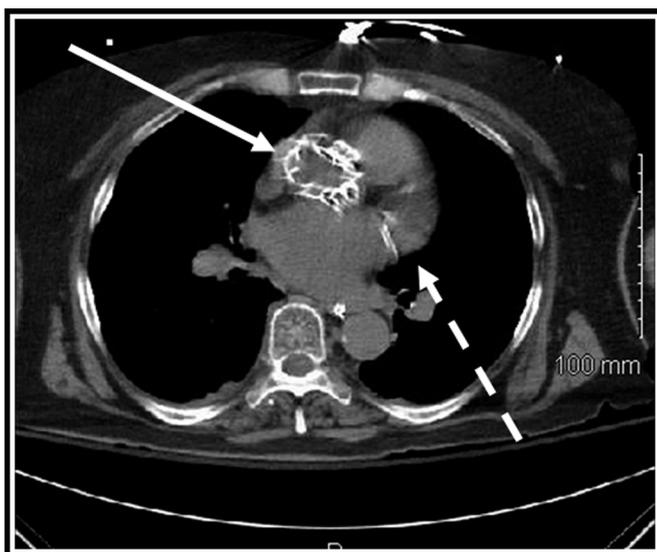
Preoperative computed tomography scan demonstrating previous self-expandable TAVR (solid arrow) and mitral annular calcification (dashed arrow).
